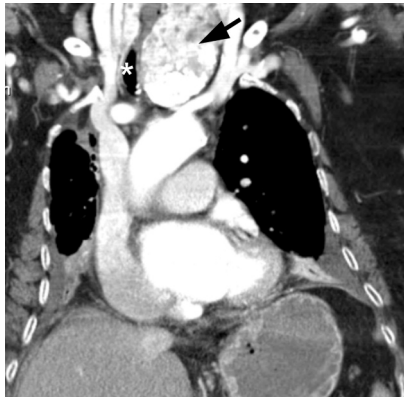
Thoracic CT scan: slice showing large intra-thoracic goiter with gross calcifications (arrow) which caused tracheal compression and displacement with lumen reduction to a minimum of 6 mm (asterisk).
